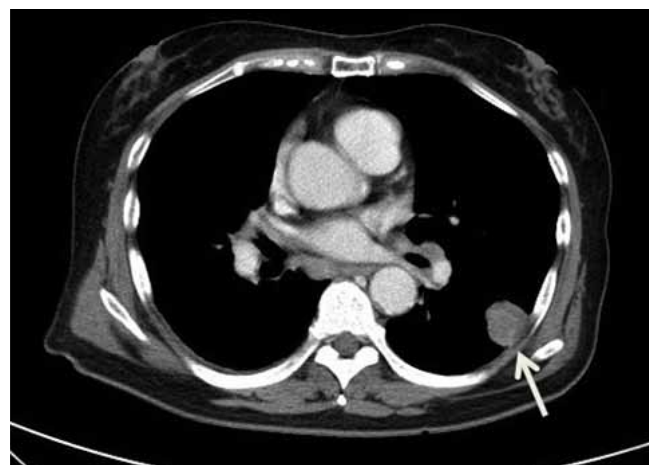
Chest computed tomography axial series with mediastinal window after infusion of intravenous contrast, showing ultrafine nodule in the left lower lung.
